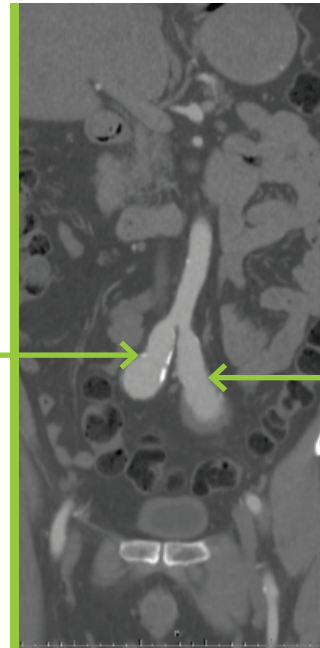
Coronal reconstruction of CT scan demonstrating bilateral large, fusiform common iliac artery aneurysms (green arrows).
